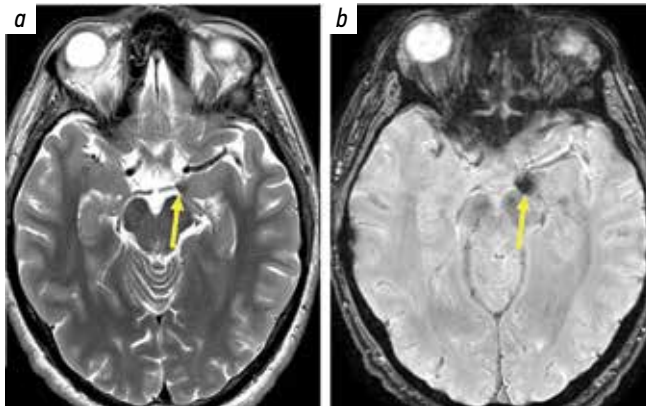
Contrast-enhanced magnetic resonance imaging of the brain of patient A. according to the epilepsy protocol, T2-weighted (a) and SWAN (b). Cavernoma of the left temporal lobe uncus with non-homogenous hypointense structure in all MRI sequences, with cloud-like accumulation of hemosiderin on the margins, size $6 \times 4 \times 5$ mm (yellow arrows)
